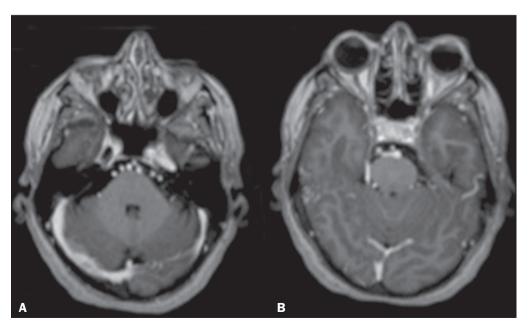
Female patient diagnosed with Behçet's disease. Contrast-enhanced T1-weighted MRI scan of the skull showing entanglement of vessels in the prepontine cistern supplied by dural branches of enlarged caliber, with a fistula to the right sigmoid sinus, consistent with dural fistula.
